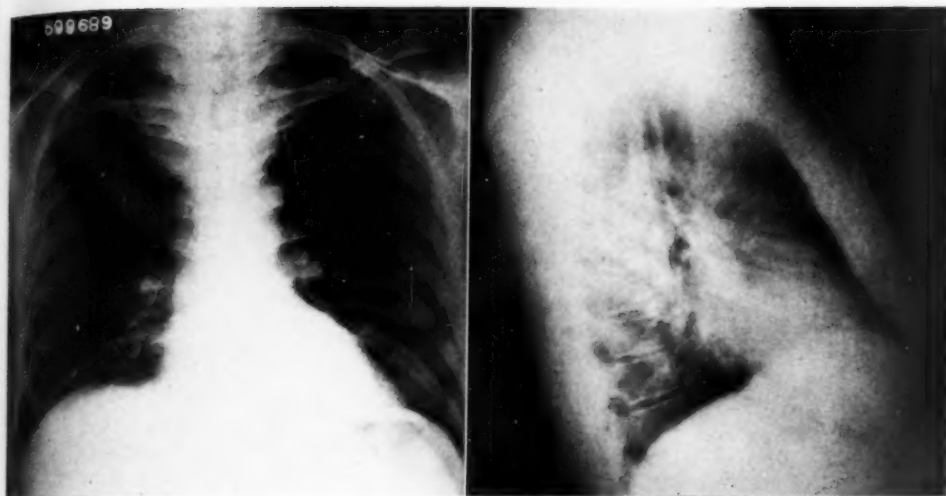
R. M., a 56-year-old white male, entered the hospital for a physical check-up and regulation of a mild diabetes. The goiter was an incidental finding. Physical examination disclosed a slight dilatation of the neck veins and a small palpable mass in the right neck. A chest roentgenogram brought to light a mass in the anterior superior mediastinum, which displaced the trachea posteriorly and to the left. It was slightly nodular and showed no calcification. A reflection of the mediastinal pleura below the goiter at the base of the heart is seen. This goiter did not move with swallowing, and at operation the surgeon, Dr. Richard H. Sweet, found it to be tightly wedged beneath the sternum. It was removed through a cervical incision.
